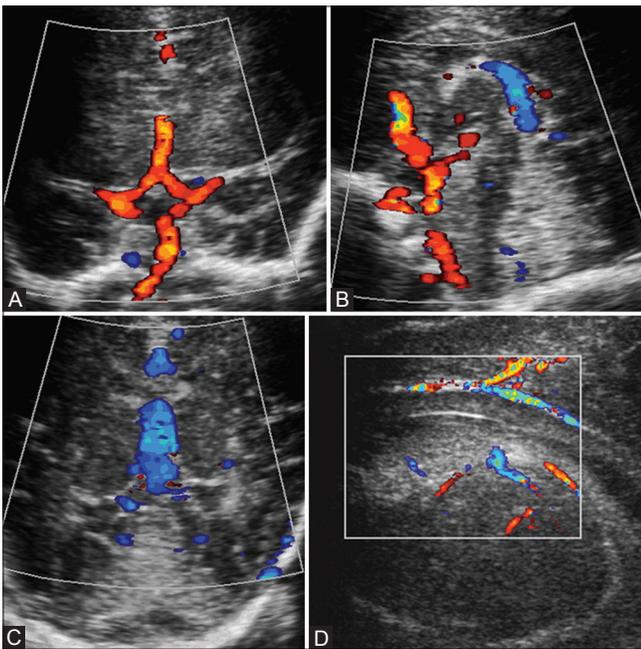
(A-D): Doppler images (A and B) demonstrating circle of Willis. Coronal USG demonstrating the vein of Galen. (C) Parasagittal study showing the small periventricular veins in the region of caudothalamic groove (D)
